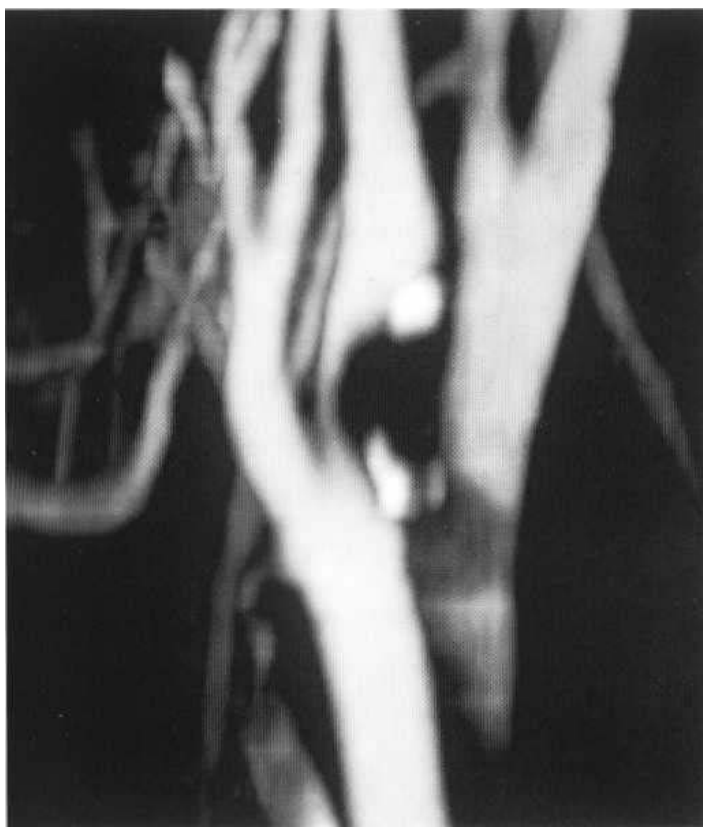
Maximum-intensity projection image from spiral CT dataset showing severe stenosis of proximal internal carotid artery. The calcification within the plaque is clearly seen.
